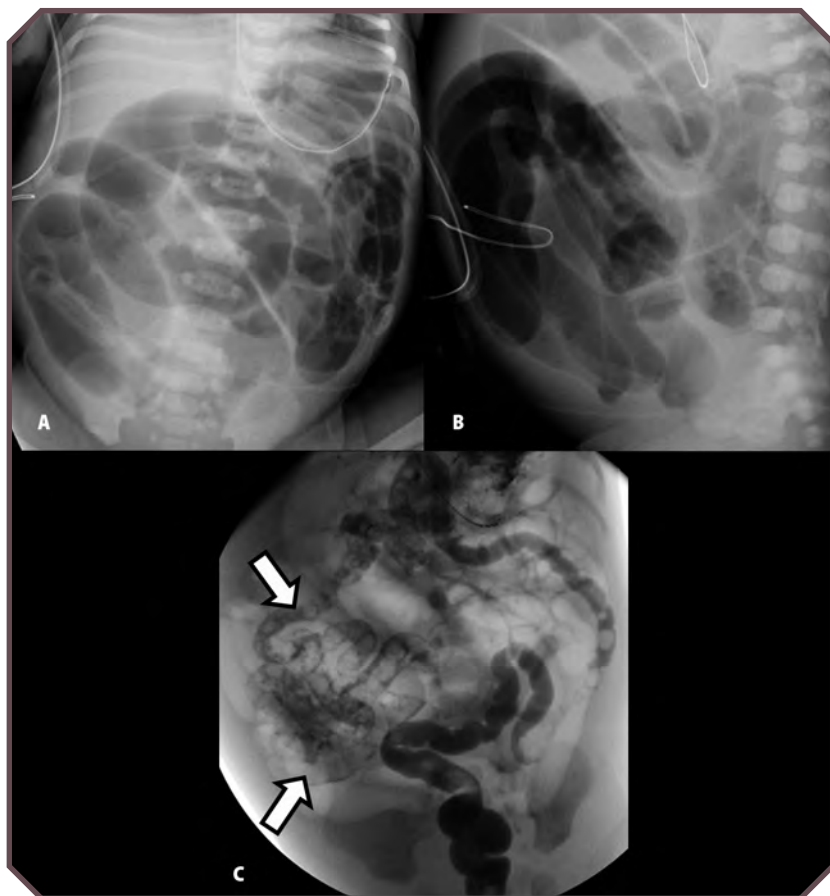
Meconium ileus in a 1.5-day-old male newborn who has not passed meconium. A. Frontal and B. lateral radiographs show multiple dilated bowel loops without rectal gas, indicating small-bowel obstruction. C. Frontal image obtained from a contrast-enhanced enema demonstrates a microcolon and multiple filling defects in the distal ileum (arrows).
